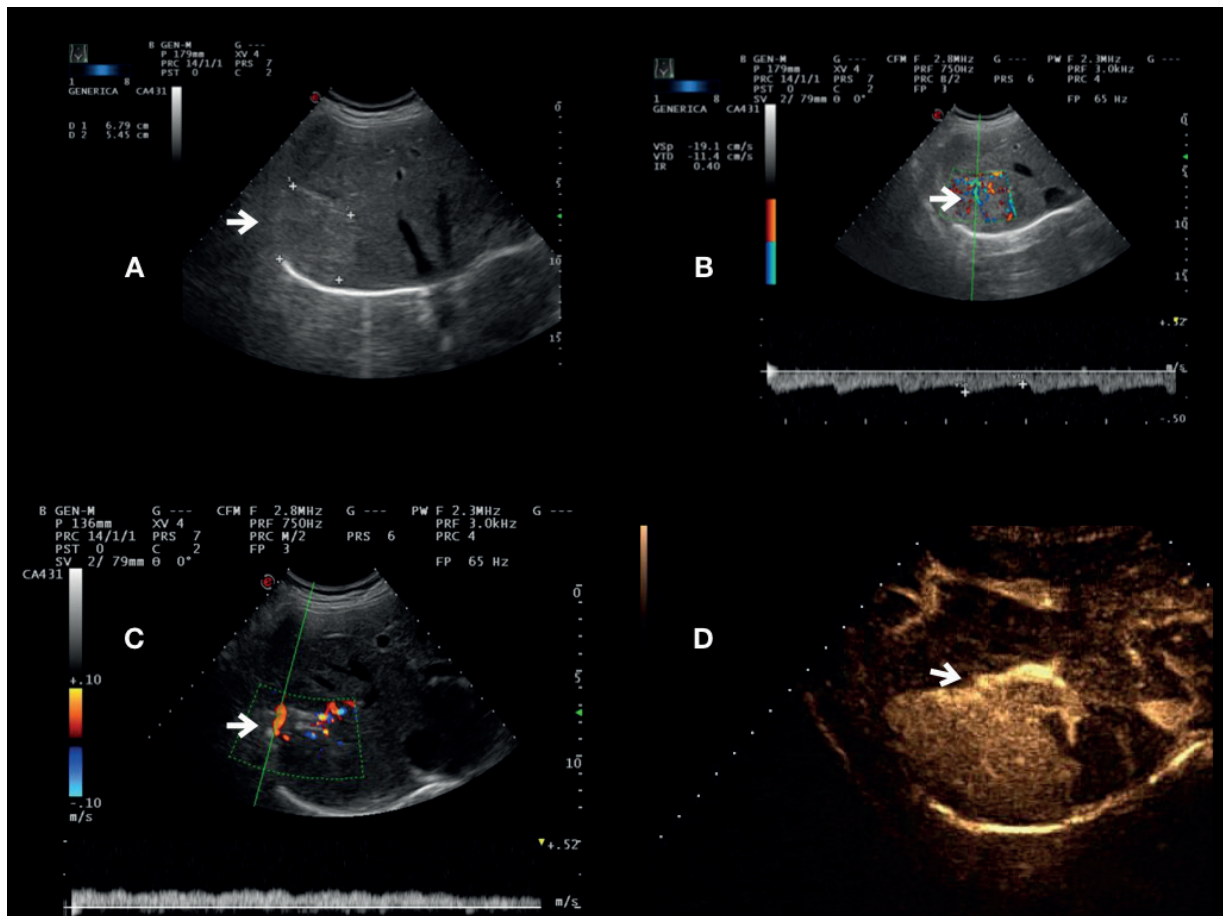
A 45 years old woman with a 6.8 cm FNH of the segment VII, studied by conventional ultrasound (panel A), color and pulsed wave Doppler (panels B and C) and CEUS (panel D). Panel A, Hyperechoic lesion at B mode US. Panel B, color and pulsed wave Doppler evaluation demonstrate the presence of intratumoral flow with the typical arterial spectrum characterized by the spoke-wheel sign and low resistivity index (*white arrow*). Panel C, evidence of peripheral venous flow coming out from the lesion, detected by both color and pulsed wave Doppler analysis (*white arrow*). Panel D, CEUS shows the persistence of enhancement during the venous phase. The *white arrow* indicates a venous vessel coming out from the lesion.
